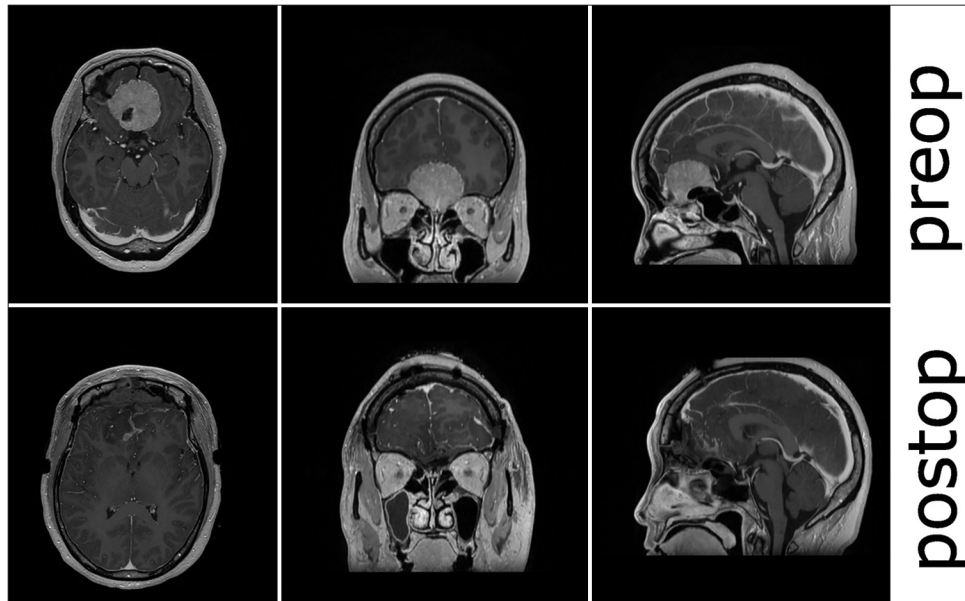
Post contrast pre- and postoperative day 2 magnetic resonance imaging scans. Of note is a gross total resection with expected postoperative changes and no evidence of a lesion that would have explained a focal cranial nerve deficit.
